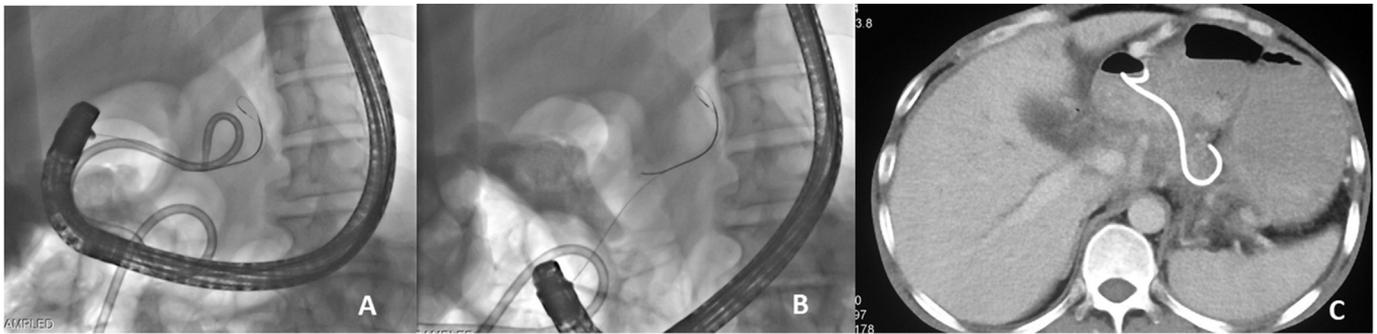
A: The transgastric catheter site cannulated alongside the PCD and the guide wire manipulated into the fistula tract. B: The PCD removed and guide wire secured in the fistula tract. C: CT: The transmural stent in situ.
